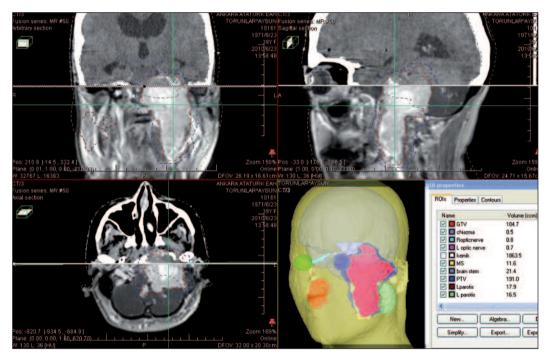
Sagittal, coronal, and axial images of CT registered to MR and 3-D image reconstruction, of the first case.
